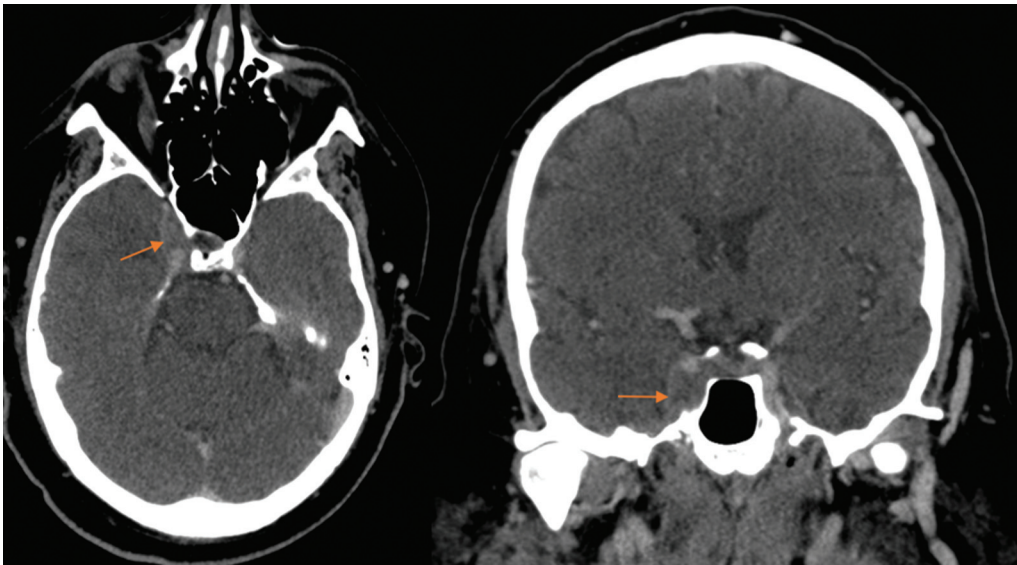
Computed tomography (CT) venogram demonstrating cavernous sinus thrombosis in axial (left) and coronal (right) views.
